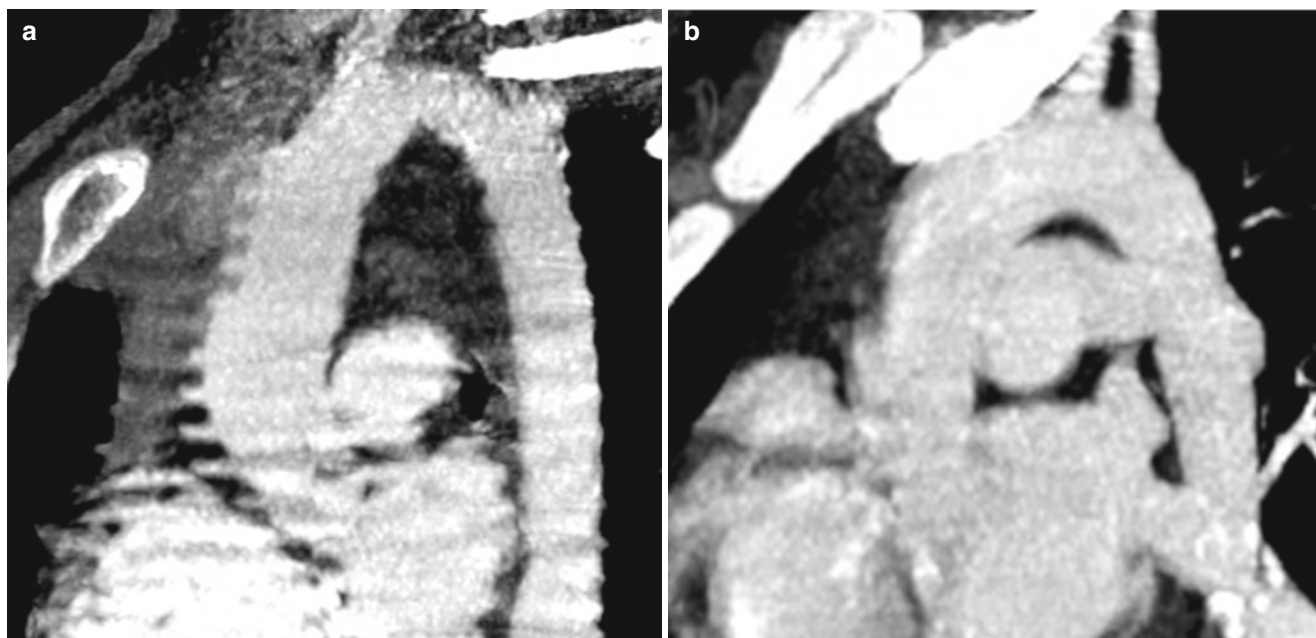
Effect of scan speed on motion artifact. Both aorta scans are non-gated scans. Single-slice CT (a) scan shows more severe motion artifacts than that of a 16-channel MDCT scan (b). Cardiac motion artifact and respiratory motion artifact can be minimized by faster scanning
